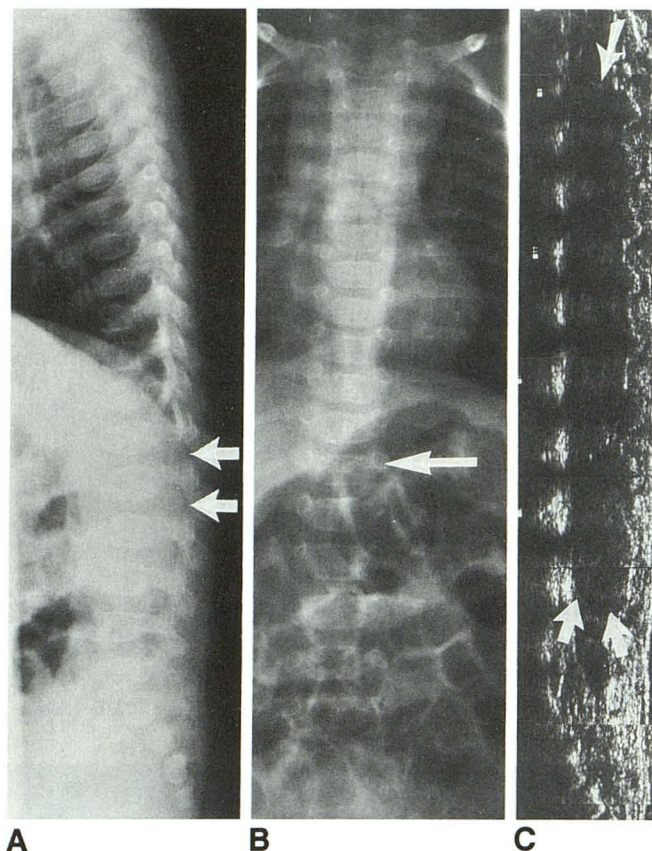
Four-month-old boy with a 2-month history of micturition disturbances who was admitted for further investigation. A few hours after admission, he developed a paraplegia. A lateral spinal radiograph (A) shows some discrete scalloping of the dorsal surface of the lower thoracic and upper lumbar vertebral bodies with widening of the intervertebral foramina of L1-2 and L2-3 (arrows). Increased interpedicular distance of T-12 is seen on a frontal film (arrow, B). Sonography (C) demonstrated an intraspinal tumour extending from the eighth thoracic vertebral body (arrow) to the fourth lumbar vertebral body (arrows). He was referred to another hospital for further imaging and operation. The final diagnosis was a poorly differentiated Ewing sarcoma.
